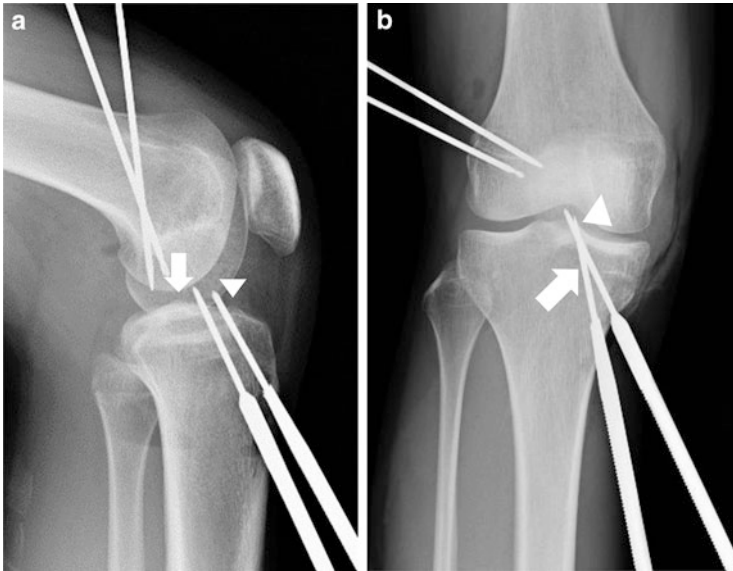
Intraoperative X-rays.
